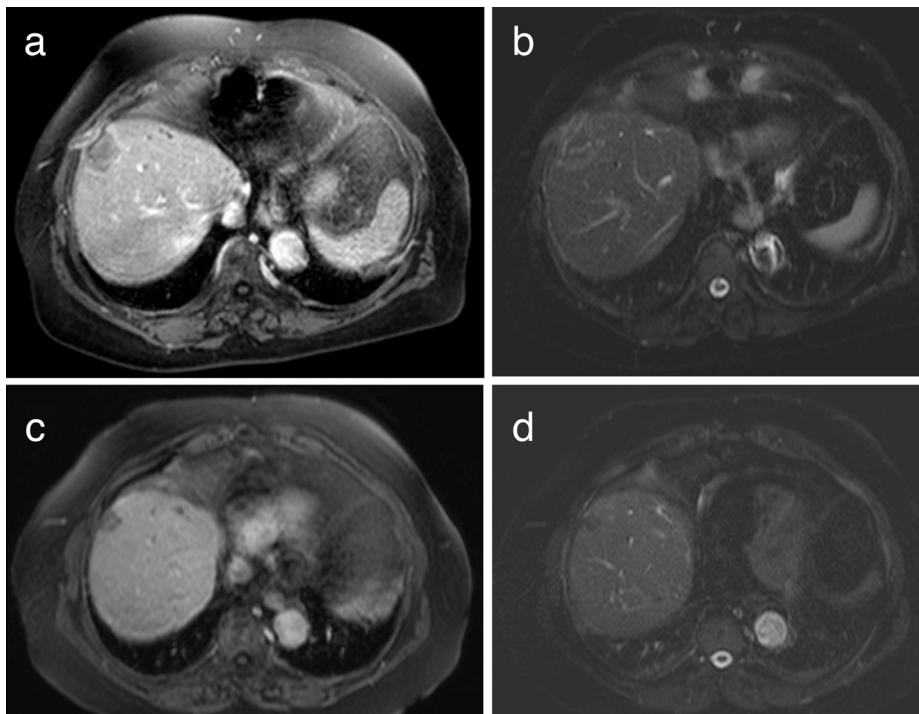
Costochondritis after RFA of HCC. A patient with segment 8 HCC who underwent RFA one month ago has right upper quadrant pain that does not resolve. Follow-up MRI in the first month shows a costochondral inflammatory signal increase adjacent to the ablation zone in the postcontrast T1 (a) and fat-suppressed T2 slices (b). At the sixth month follow-up, the postcontrast fat-suppressed T1 (c) and fat-suppressed T2 (d) slices show a regression of costochondral inflammation and a shrunken ablation cavity. RFA, radiofrequency ablation; HCC, hepatocellular carcinoma; MRI, magnetic resonance imaging.
